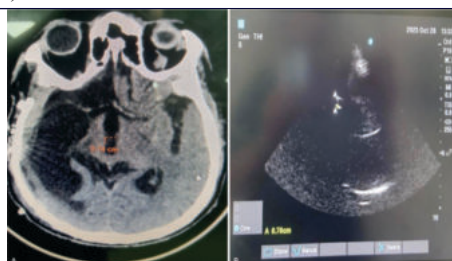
(A) Post-operative third ventricular width on CT image; (B) Post-operative third ventricular width on ultrasonography.
